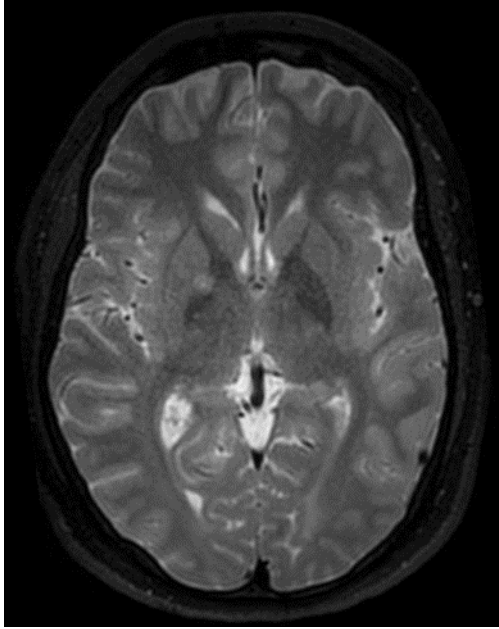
High field MRI, T2WI, axial section, hypointense lesion at the level of the right basal ganglia with hyperintensity central
